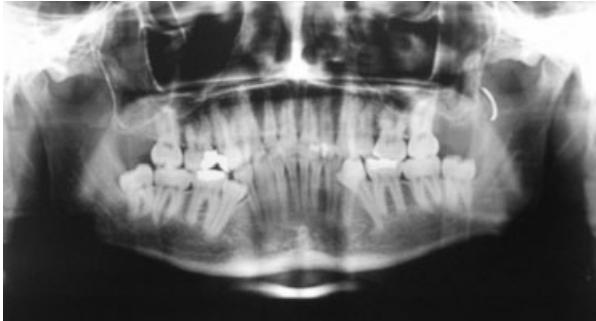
The image of the needle on the panoramic radiograph.
